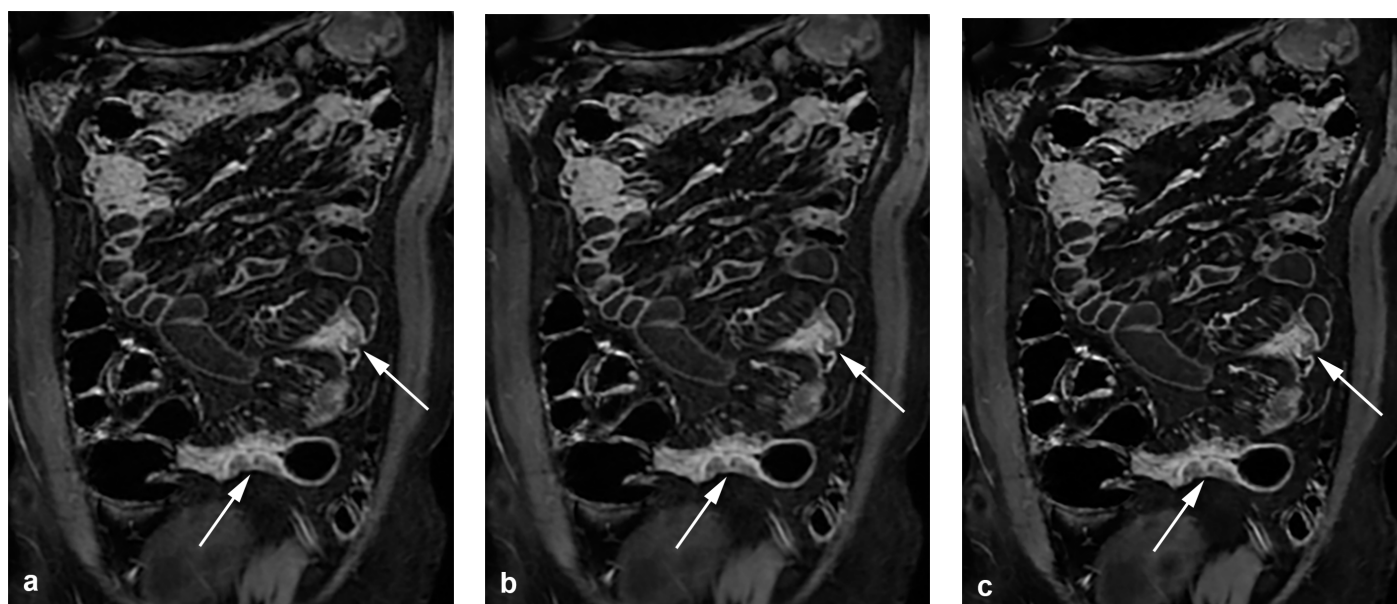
Dynamic enteric phase contrast-enhanced T1-weighted images of a 30-year-old man with active Crohn's disease. Three sets of coronal images were obtained, each with (a) conventional reconstruction and no image filter (original); (b) with conventional reconstruction and image filter (filtered); and (c) with deep-learning reconstruction (DLR) at the noise-reduction level of 75% (DLR). The DLR image (c) shows increased sharpness of bowel walls and mesenteric vessels, enabling better visualization of active inflammation of bowel segments and adjacent comb signs (arrows). A reduction of noise with a slight synthetic appearance is also noted in the DLR image (c) compared with the other two images (a, b).
